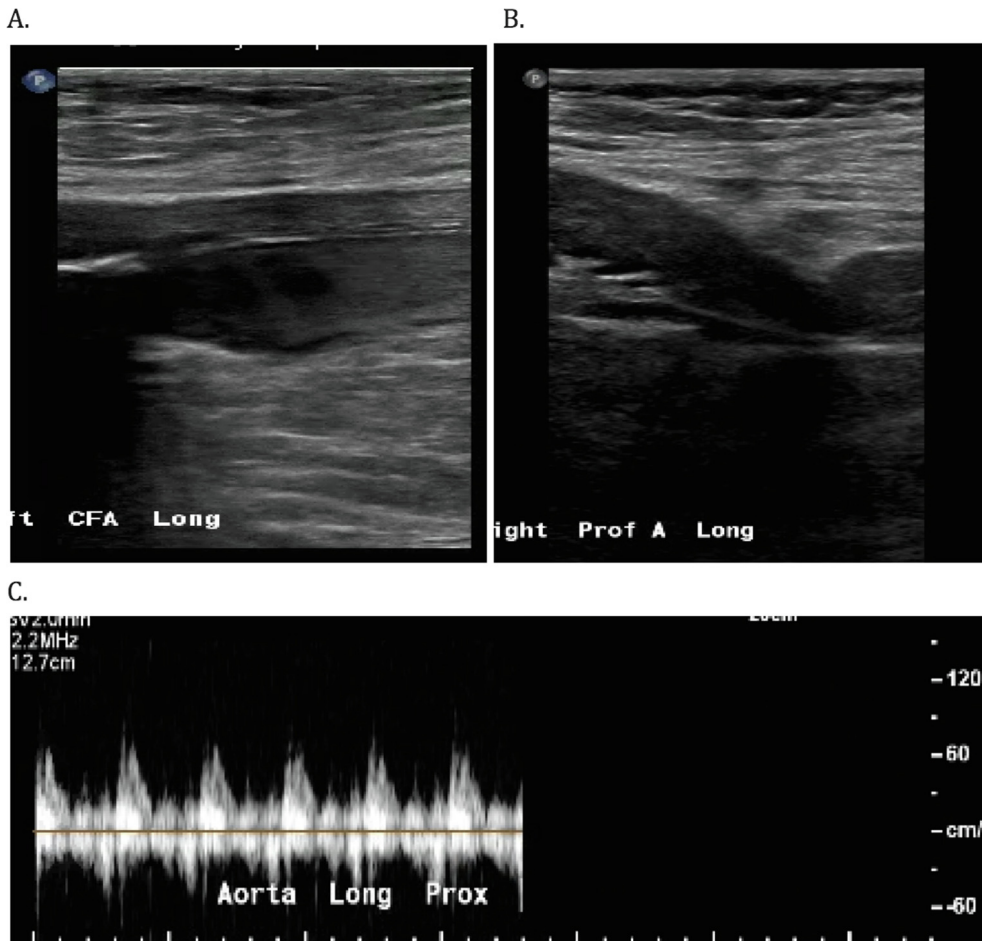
(A) Left common femoral and (B) profunda femoris artery with a large occluding thrombus in the lumen and negative biphasic flow on Doppler ultrasound. (C) Biphasic flow waveform demonstrating absence of blood flow below proximal part of the femoral artery.
